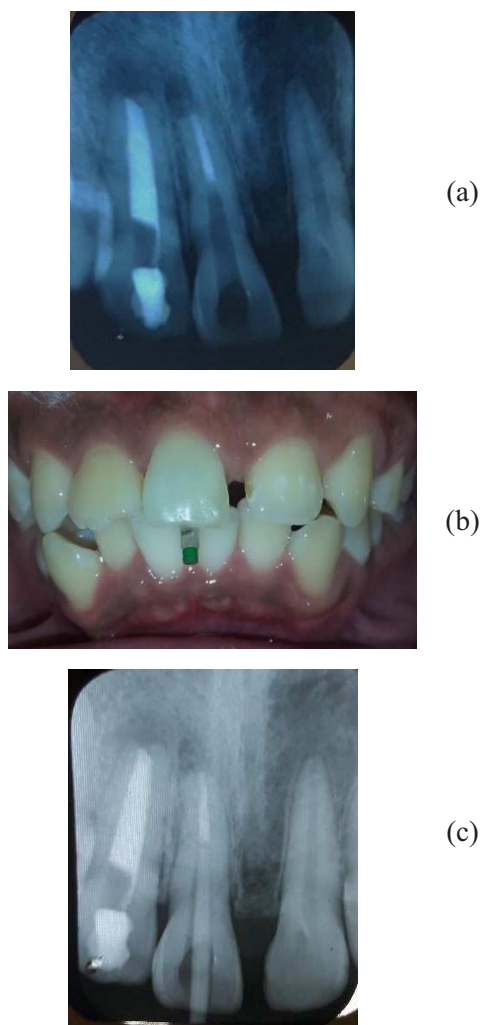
(a) Gutta percha removal at tooth 11, (a) Clinical photograph of trial insertion, (c). Radiograph checking of trial insertion.
